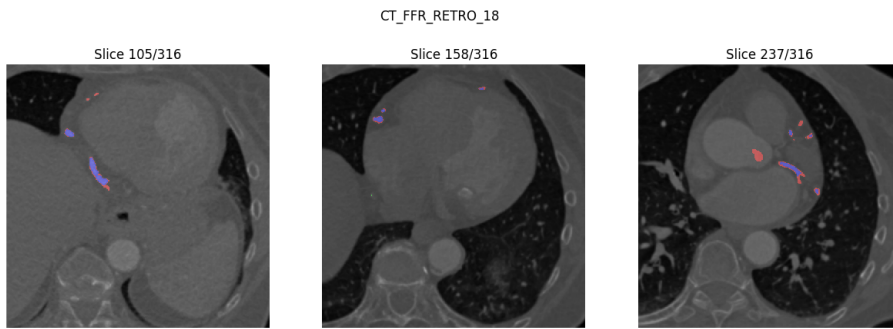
A selection of some of the CT slices of the SegCaps model’s worst prediction of the coronary artery split-0, where the corresponding prediction is overlaid. The prediction is color-coded with blue=TP, green=FP, and red with low opacity=FN
